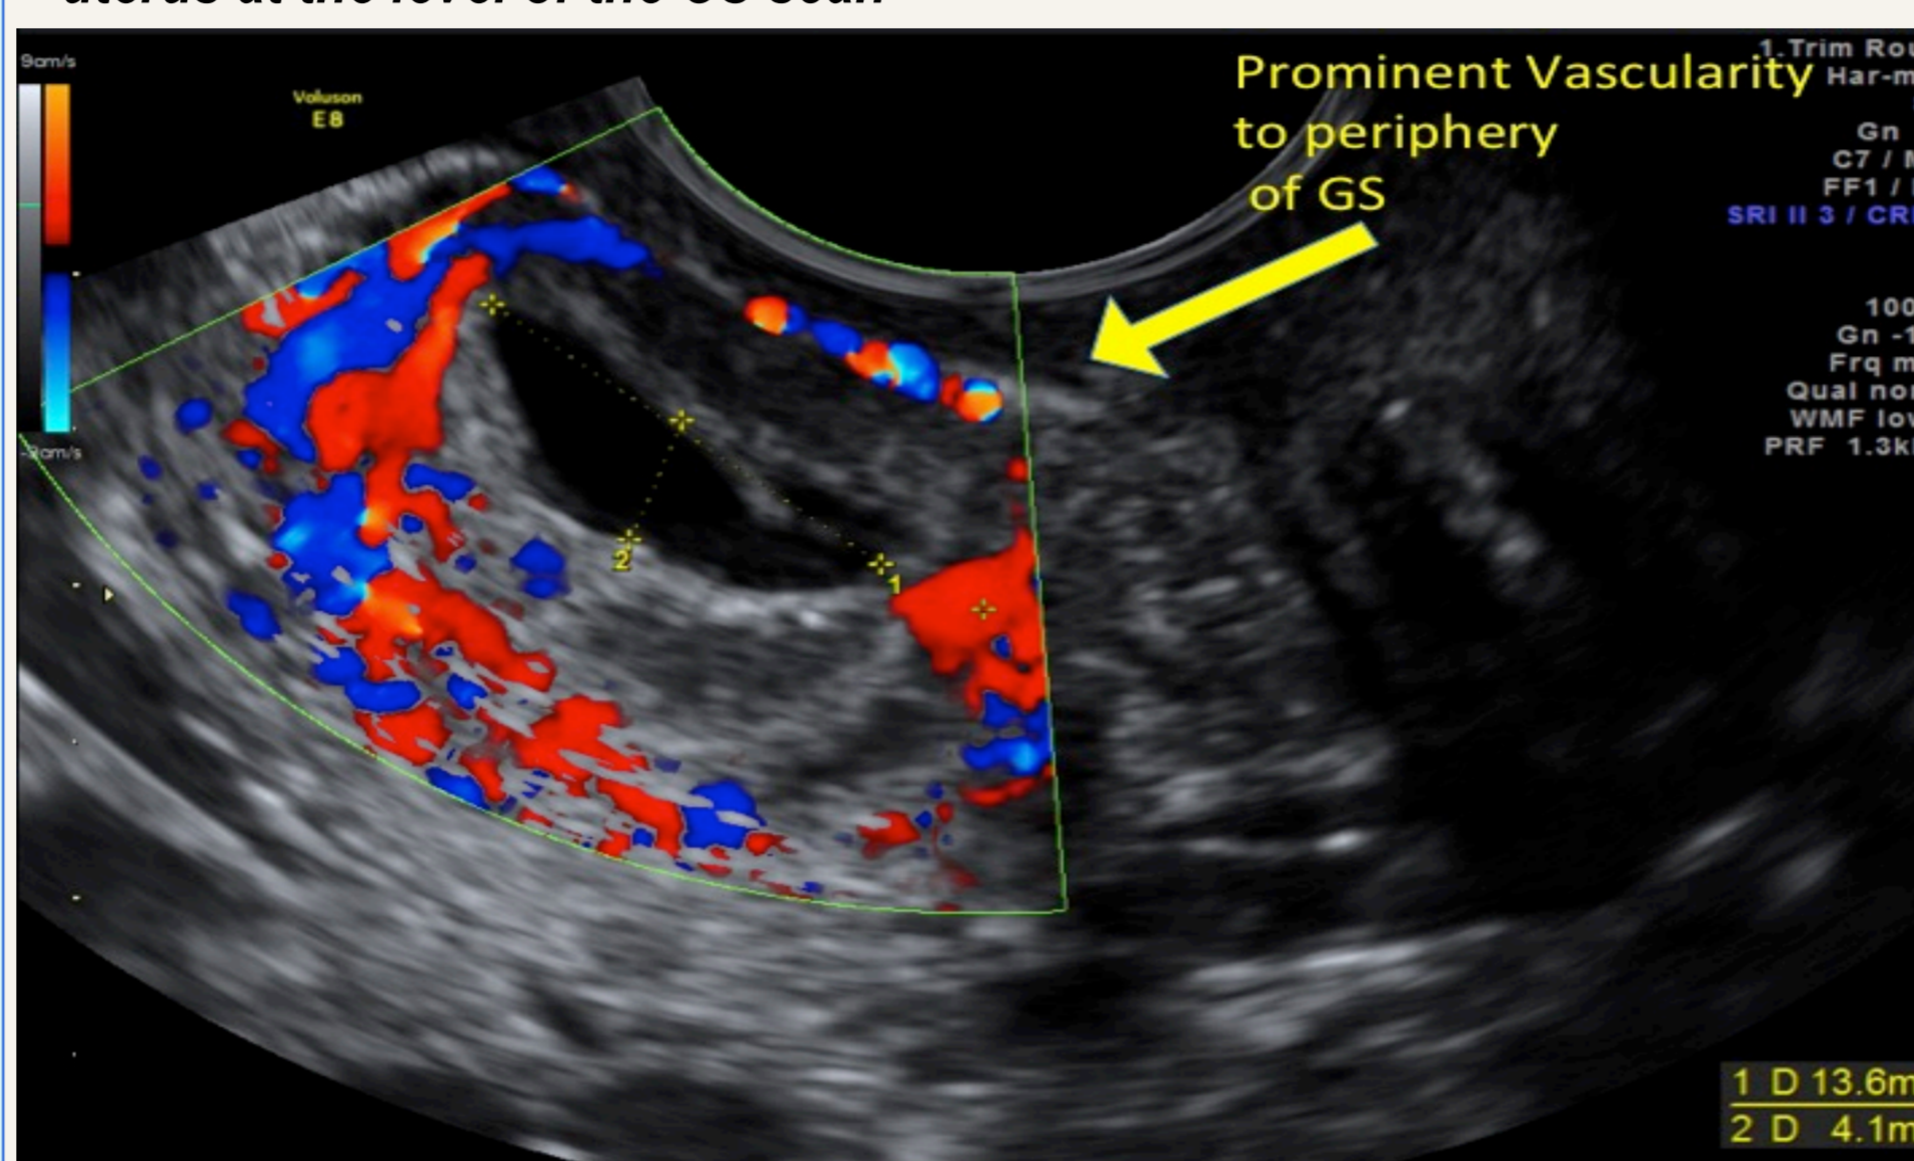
The GS surrounded with significant trophoblastic flow on colour Doppler (myometrial-bladder interface absent).
